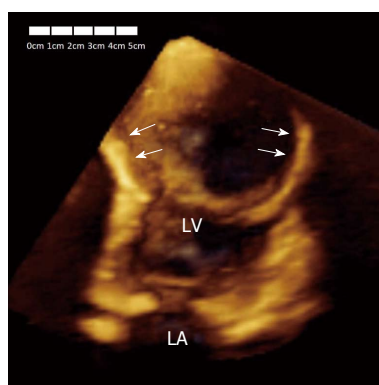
Three-dimensional echocardiography in apical four chamber view showing the big size of the aneurysm (arrows). LA: Left atrium; LV: Left ventricle.
